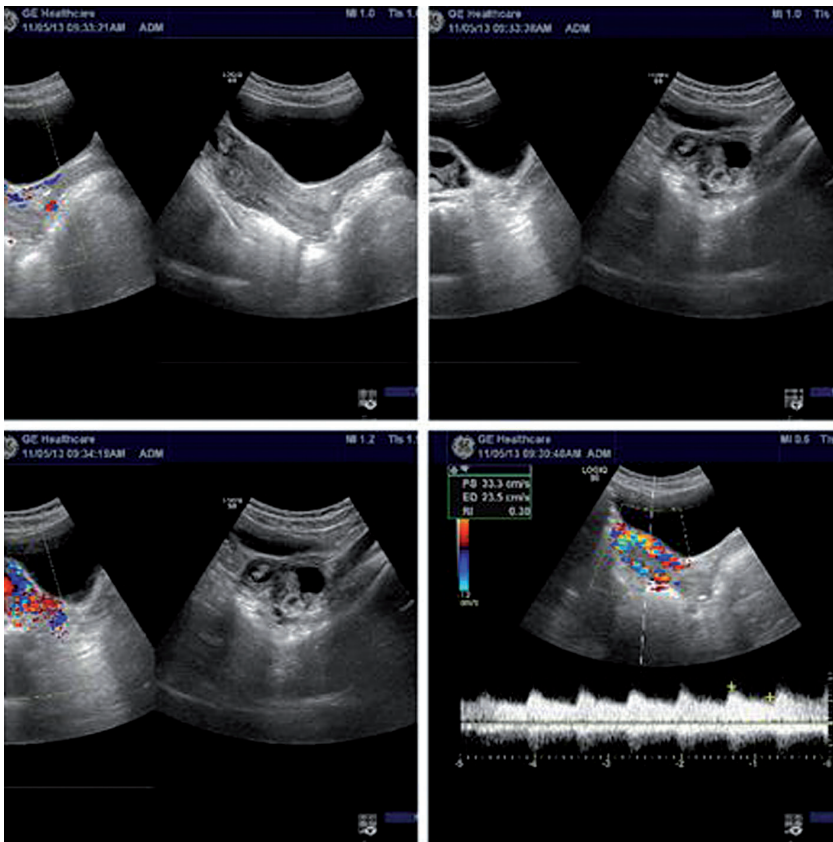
Color ultrasonography performed on November 4, 2013.
